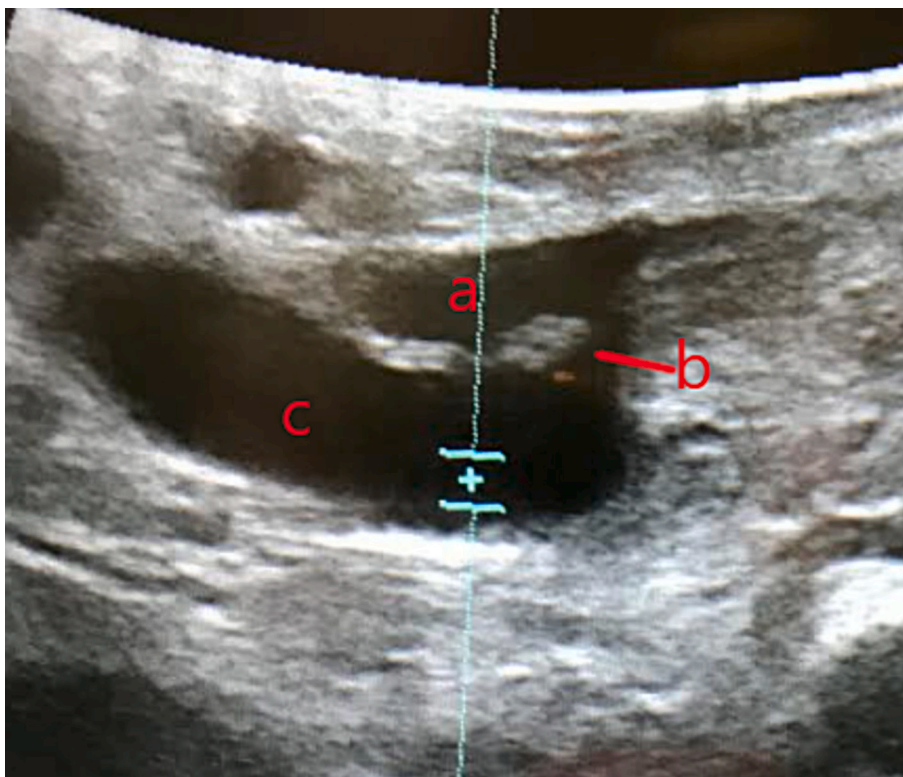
Perioperative ultrasonography showing the gastroduodenal artery (a), the portal vein (c) and the traumatic arterioportal fistula between the two vessels (b).
